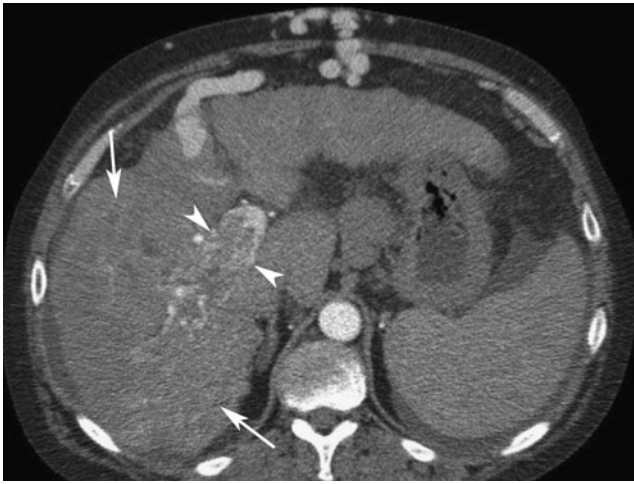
Fifty-three-year-old man with alcoholic cirrhosis and hepatocellular carcinoma. Axial contrast-enhanced CT in the arterial phase shows thrombus in the right portal vein (*arrowheads*). Small enhancing vessels seen within the thrombus indicate the presence of tumor. The infiltrative HCC (*arrows*) in the right hepatic lobe is difficult to appreciate. Stigmata of portal hypertension are seen, including ascites and caput medusae
